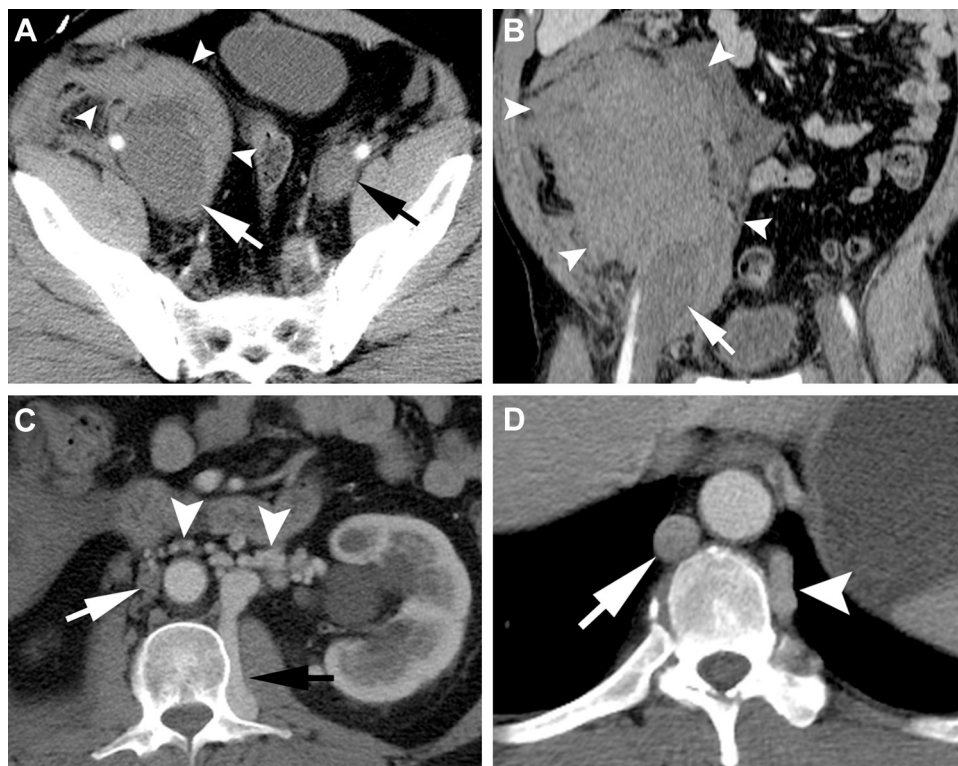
A, Axial computed tomography (CT) image with intravenous administration of contrast material demonstrating the ruptured right common iliac vein aneurysm (*white arrow*) with surrounding retroperitoneal hematoma (*arrowheads*), as well as a left common iliac vein aneurysm (*black arrow*). B, Coronal CT image showing the ruptured right iliac vein aneurysm (*arrow*) with adjacent retroperitoneal hematoma (*arrowheads*). C, Dilated retroperitoneal collateral veins (*arrowheads*) with a diminutive inferior vena cava (IVC; *white arrow*). D, Dilated azygos (*arrow*) and hemiazygos (*arrowhead*) veins with absence of the IVC consistent with IVC agenesis.
